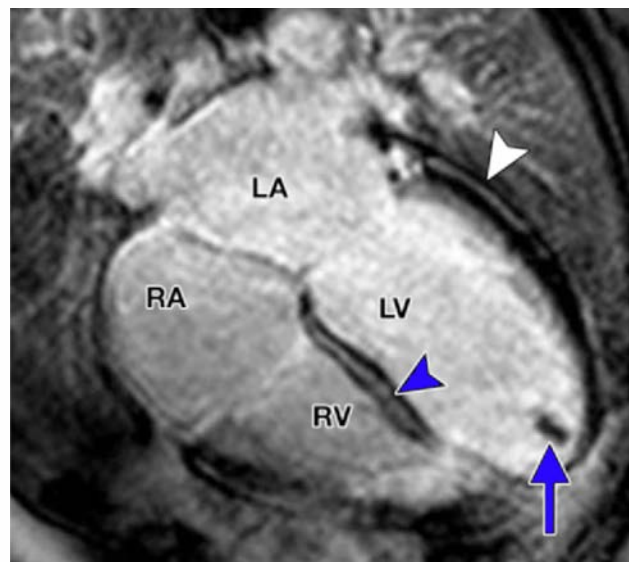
Dilated cardiomyopathy in a 36-year-old male soccer player with fatigue and a 3-5-day history of burning epigastric pain associated with nausea, vomiting, and early satiety. Horizontal long-axis late contrast-enhanced MR image shows an apical thrombus (arrow) in the left ventricle and midwall enhancement in the lateral left ventricular wall (white arrowhead) and the interventricular septum (black arrowhead) [Stojanovska J et al., 2013].
